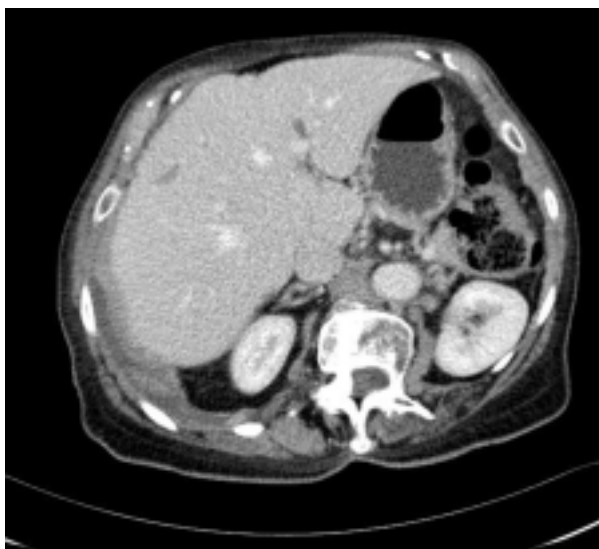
Patient's CT scanning revealing abnormal focus in the right lobe of liver
